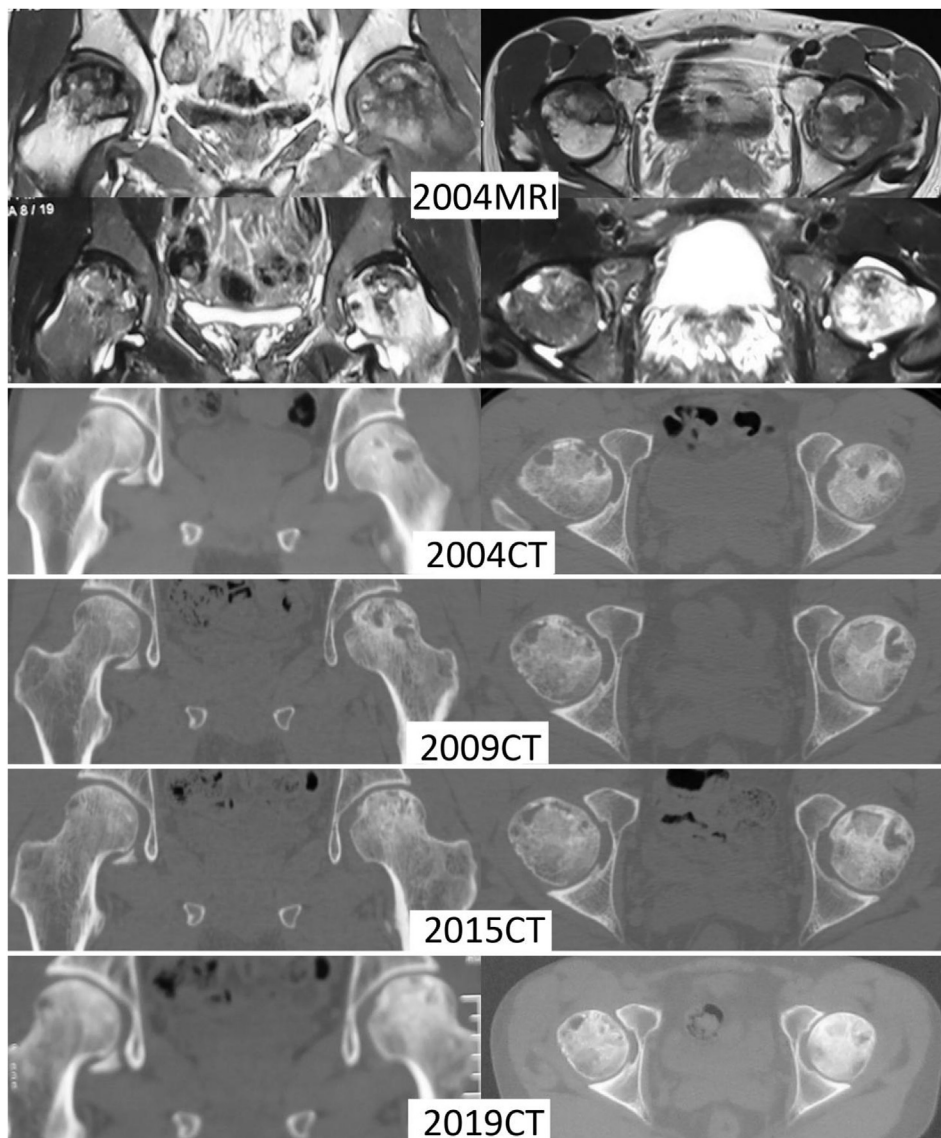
Medical imaging series from a 43-year-old male (patient number SARS03022) with ONFH received HGF therapy in 2004. MRI in 2004 suggested extensive bone marrow oedema in the left femoral head. Series CT (from 2004 to 2019) showed the development of sclerosis and cyst in the necrotic lesions. CT in 2019 demonstrated a replete sclerosis in the necrotic lesions. CT images in 2019 confirmed the presence of osteoarthritis (left: K–L Grade 2, right: K–L Grade 2) without severe depression of femoral head. CT = computed tomography; HGF = Huo-Gu formula; MRI = magnetic resonance imaging; ONFH = osteonecrosis of the femoral head.
